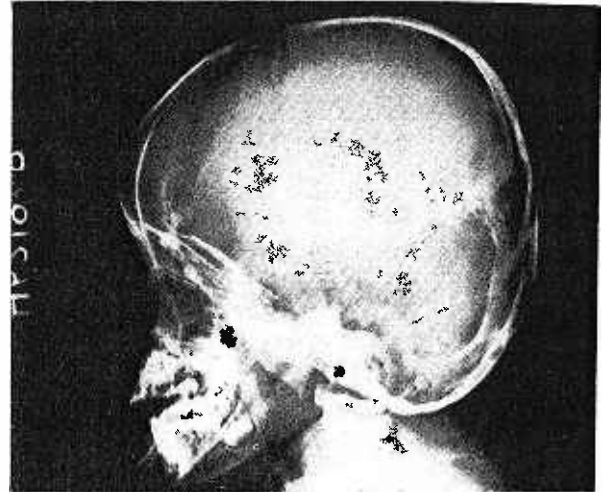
Case 2, X-ray skull showed large defect in right occipital and several smaller defects in frontal region.
